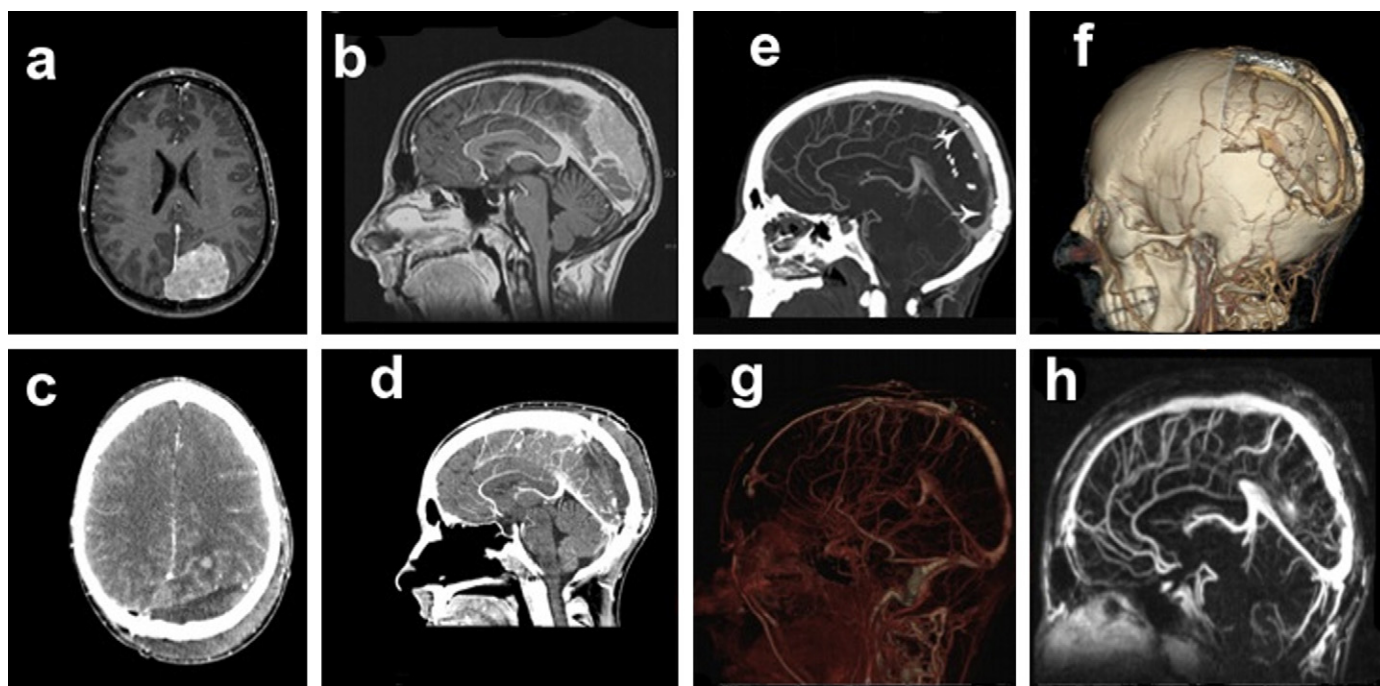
Preoperative MRI, axial (a) and sagittal (b) T1-weighted with gadolinium enhancement images showing a large parieto-occipital meningeal tumour invading the posterior one-third of the superior sagittal sinus (SSS). Early postoperative CT scan, axial (c) and sagittal (d), showing an extradural hematoma that occluded the bypass, and required evacuation; at 7th day (e), 3 months (f) (3D reconstruction, g: angiogram) and 2 years after surgery (h): the graft was patent.
